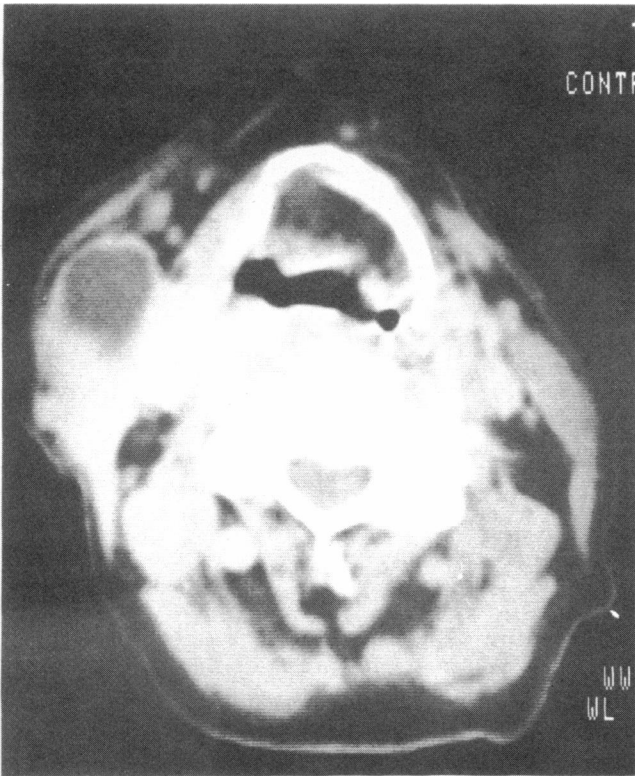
CT of neck; cystic degeneration in a squamous cell carcinoma involving a lymph node and secondary to a laryngeal tumour.
